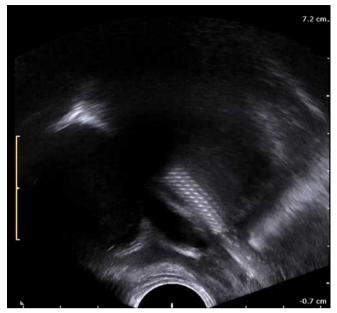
Thanks to transrectal imaging, one may trace the resectoscope tip on the ultrasound monitor. The image from the resectoscope camera enables assessment of the urinary bladder mucosa, while ultrasound shows sections through the entire wall of the bladder and its neighborhood, and presents the relationship of the resectoscope with the structures adjacent to the bladder. In this case, ultrasound guidance enables the application of the laser fiber to the bladder wall in order to make an incision precisely above the perivesical segment of the ectopic ureter. Due to the differences in ultrasound wave scattering in different tissues, the resectoscope tip is seen as bent, which should be considered an artifact. The examination was performed with a transrectal end-fire probe with the frequency of 12 MHz (ProFocus Ultraview, BK Medical, Denmark)
